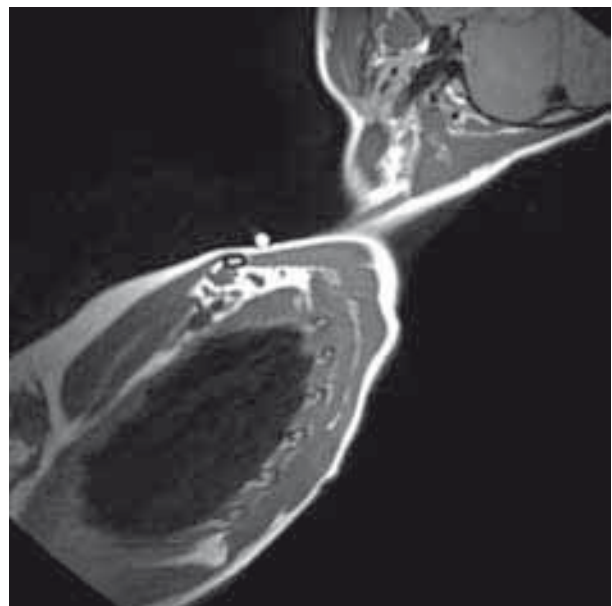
T1 weighted MRI, oblique view, with the levator claviculae muscle perpendicular to the clavicle shaft, clearly visible at the location of the marker.
